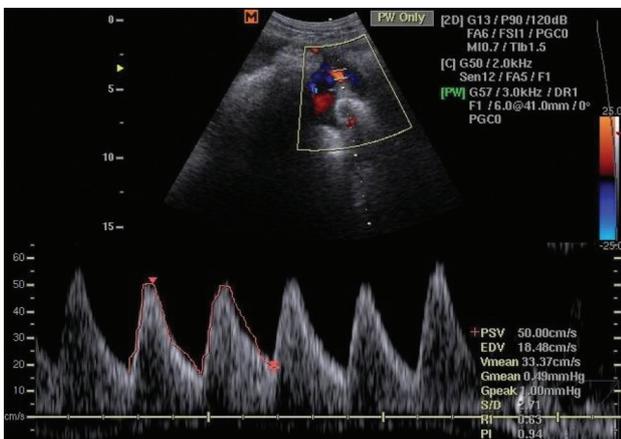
Umbilical artery Doppler for non-diabetic pregnant woman.
